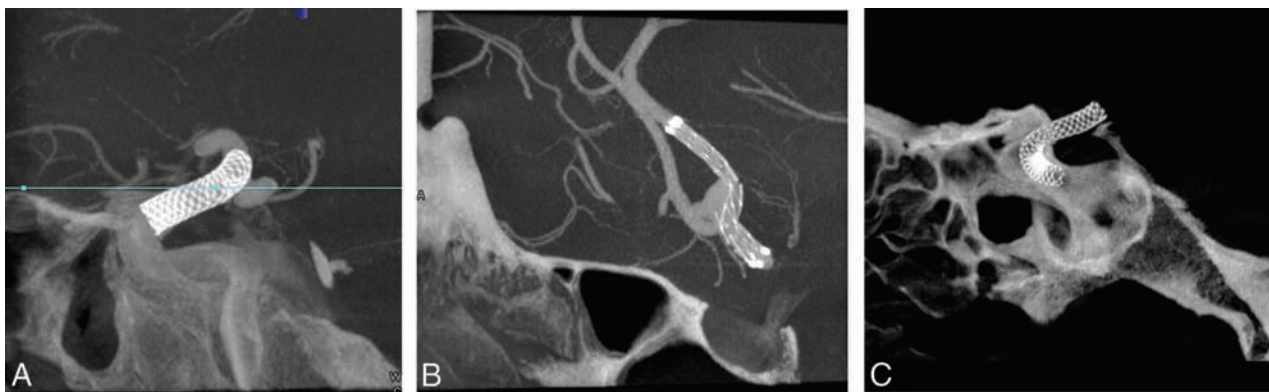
Sample cross-sections from the ATRACT reconstruction of VOI C-arm CT images from the patient cohort. VOI images show clear visibility of stent and flow-diverter devices and their relationship with the parent artery.
